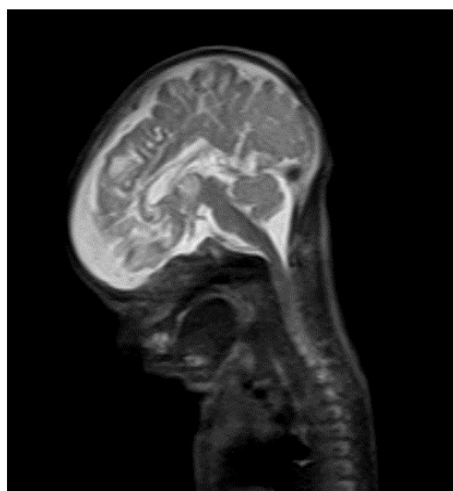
Case 1 – fetal MRI (36 Weeks' GA). Sagittal and coronal MR T2-W images in a 36 weeks'GA fetus show thrombosis of the lateral transverse sinus and superior sagittal sinus (hyperintense mass) and bilateral subcortical ischemic lesions with corpus callosum thinning.
